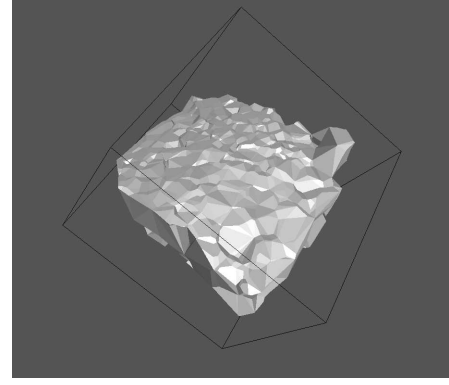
Global navigation on intra-operative data: Robot-based 3D ultrasound skull profile [Stolka07a]
